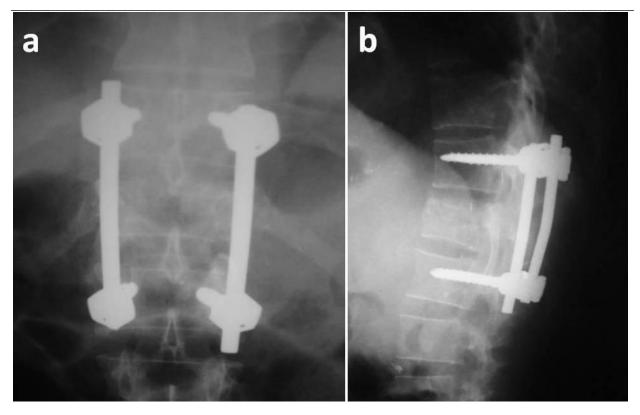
a-b: Anteroposterior and lateral radiograph of thoracolumbar spine of same patient after 6 months follow up showing well maintained height of D12 vetebra and curvature of spine along with stable pedicle and rod construct.
